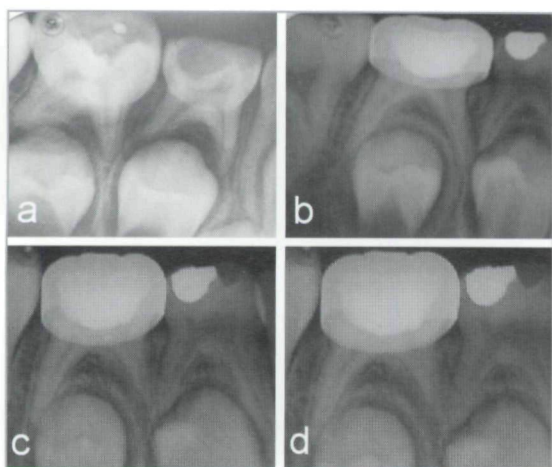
(a) Pretreatment radiograph of tooth #K. Radiographic follow-up of calcium hydroxide and Ankaferd Blood Stopper pulpotomy at (b) 3 months, (c) 6 months, and (d) 12 months.
